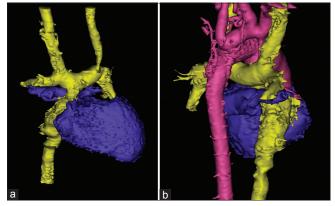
Three-dimensional computed tomography rendering of Fontan circulation (yellow) from anterior (a) and right-posterior (b) perspective with relation to the aorta/systemic arteries (pink) and heart (blue)
